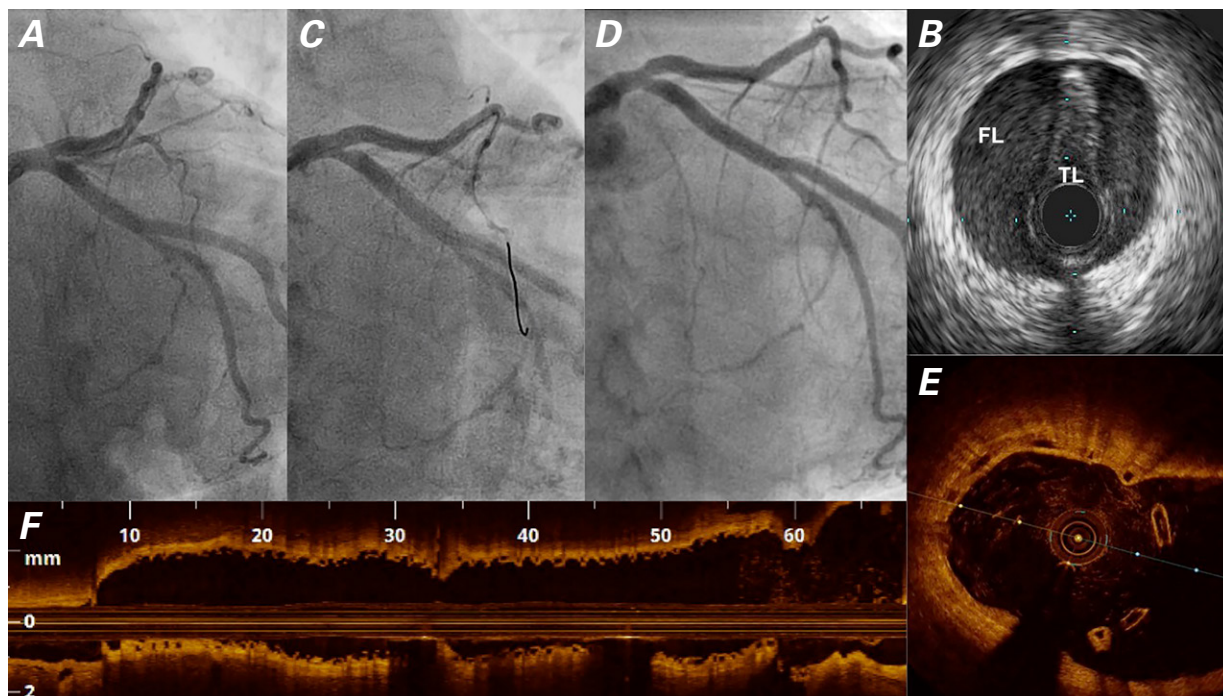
Patient 2. A) Angiogram shows a linear intraluminal filling defect extending to the mid left anterior descending coronary artery, corresponding with a spiral type 1 spontaneous coronary artery dissection from the ostium to the first diagonal branch. B) Diagnostic intravascular ultrasonogram confirms the correct position of the guidewire in the true lumen (TL) and shows an enlarged false lumen (FL). C) Angiogram shows final results after intervention. At one year, the D) angiogram and optical coherence tomograms in the E) axial view and F) long view at the bifurcation show excellent results.
